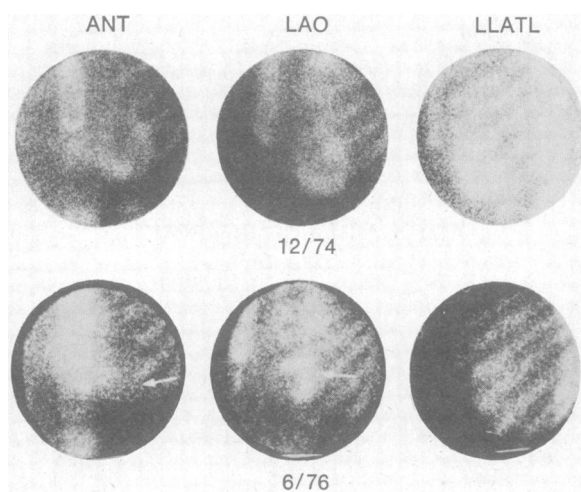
Remnant discrete uptake. Above (upper panel) are the TcPYP scintigrams in the anterior (ANT), left anterior oblique (LAO) and left lateral (LLATL) projections done at the time of acute anteroapical infarction. The scintigram is abnormal with a discrete 3 to 4+ accumulation in the anterior wall and apex of the left ventricle. Lower panel, scintigrams done in the same patient 18 months later are shown. Although less intense than on the earlier study, the image remains abnormal with a similar 2 to 3+ accumulation (arrows). Measured acute infarct size was large and there was a documented anterior aneurysm.
